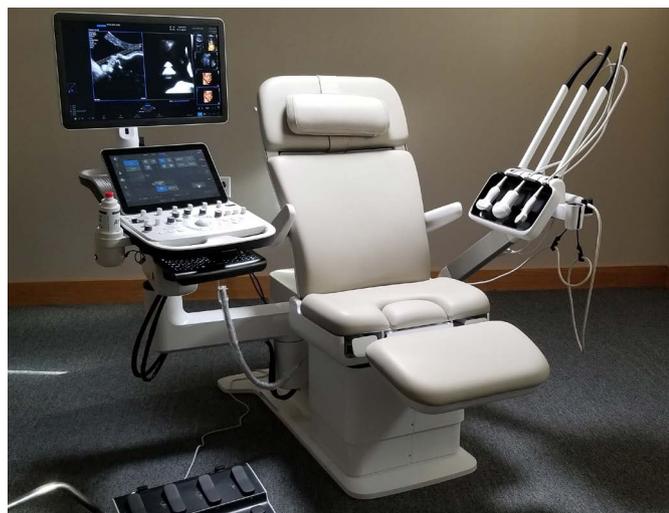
"Deconstructed" and "reconstructed" ultrasound system. This is an example of a "revolutionary" concept of separating various elements of the ultrasound system. The probes are on one side (right) of the examination chair with a probe holder with recoiling cables while the monitor and keyboard are on the other side (left) of the chair and the actual CPU under the chair.
